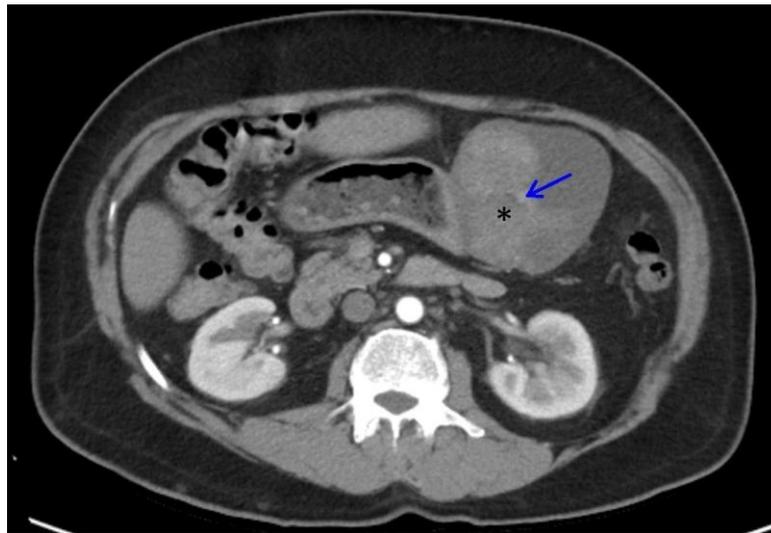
Contrast enhanced CT scan abdomen, axial view showing heterogeneously enhancing welldefined mass lesion arising from the lesser curvature with enhancing focus representing intra-tumoral bleed. 102x83mm (300 x 300 DPI)
